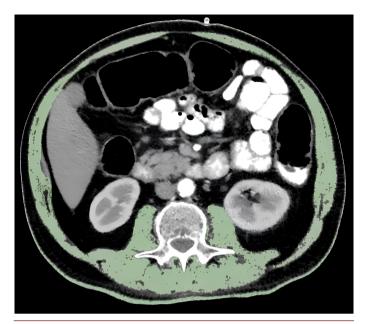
Measurements performed by OsiriX on the axial computed tomography image taken at the L3 vertebra in a patient with pancreatic cancer: skeletal muscle area.
